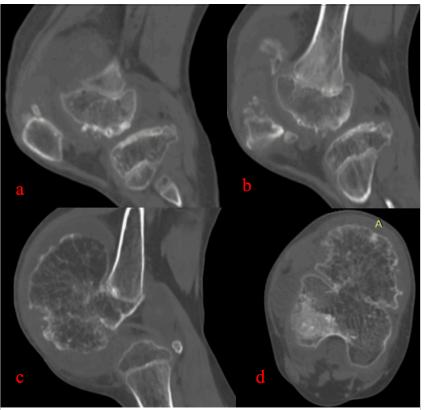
(a & b) CT of right knee showing multiple osteochondromas arising from tibial, femoral and patellar epiphysis of a 13 year old male child. (c & d) CT showing florid pedunculated osteochondroma arising from femoral epiphysis of the same child.
